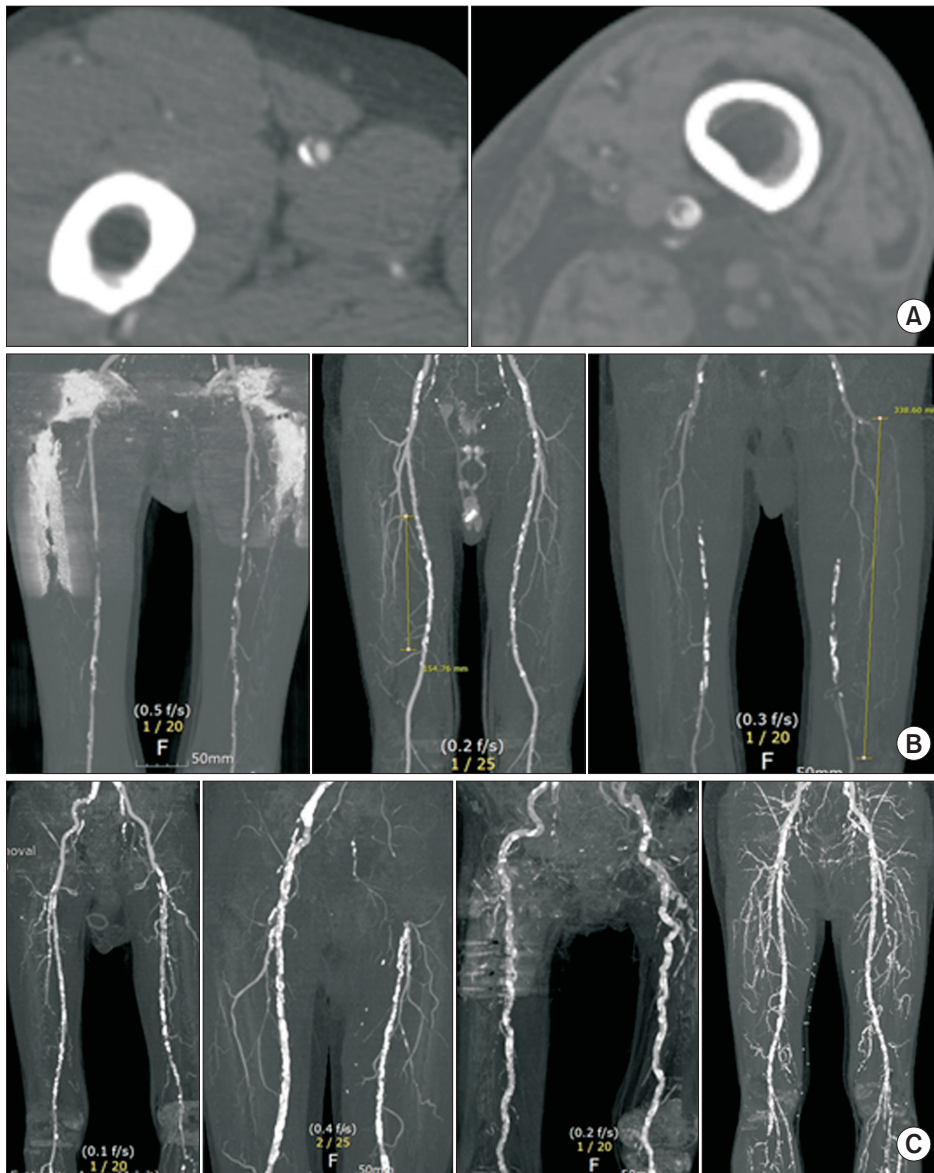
Computed tomography angiography (CTA) images showed different degree of calcification in femoropopliteal artery. (A) Circumference of femoral artery calcification in cross-sectional image; left, $<180^\circ$; right, $\geq 180^\circ$. (B) CTA images of non-severe calcification. (C) CTA images of severe calcification.
